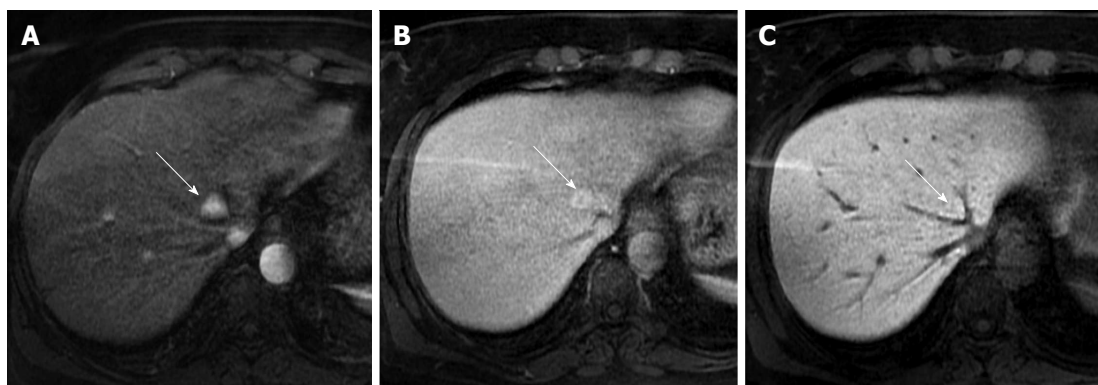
Magnetic resonance imaging of a small focal nodular hyperplasia. Arterial, venous and hepatobiliary phases (A, B and C), acquired in a 44-year-old woman shows the typical enhancement of a small focal nodular hyperplasia (white arrows). The lesion is located in the fourth liver segment, between medium and left sovrahepatic vein. In hepatobiliary phase (C) the lesion is slightly hyperintense to the surrounding liver parenchyma, due to uptake of hepatospecific contrast.
